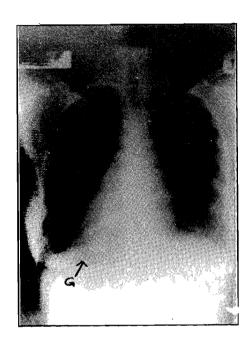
Posteroanterior (PA) chest radiograph showing the cardiac apex (A), and the gastric fundal air buble (G) on the right. Note marker L on the top left corner of the radiograph.
